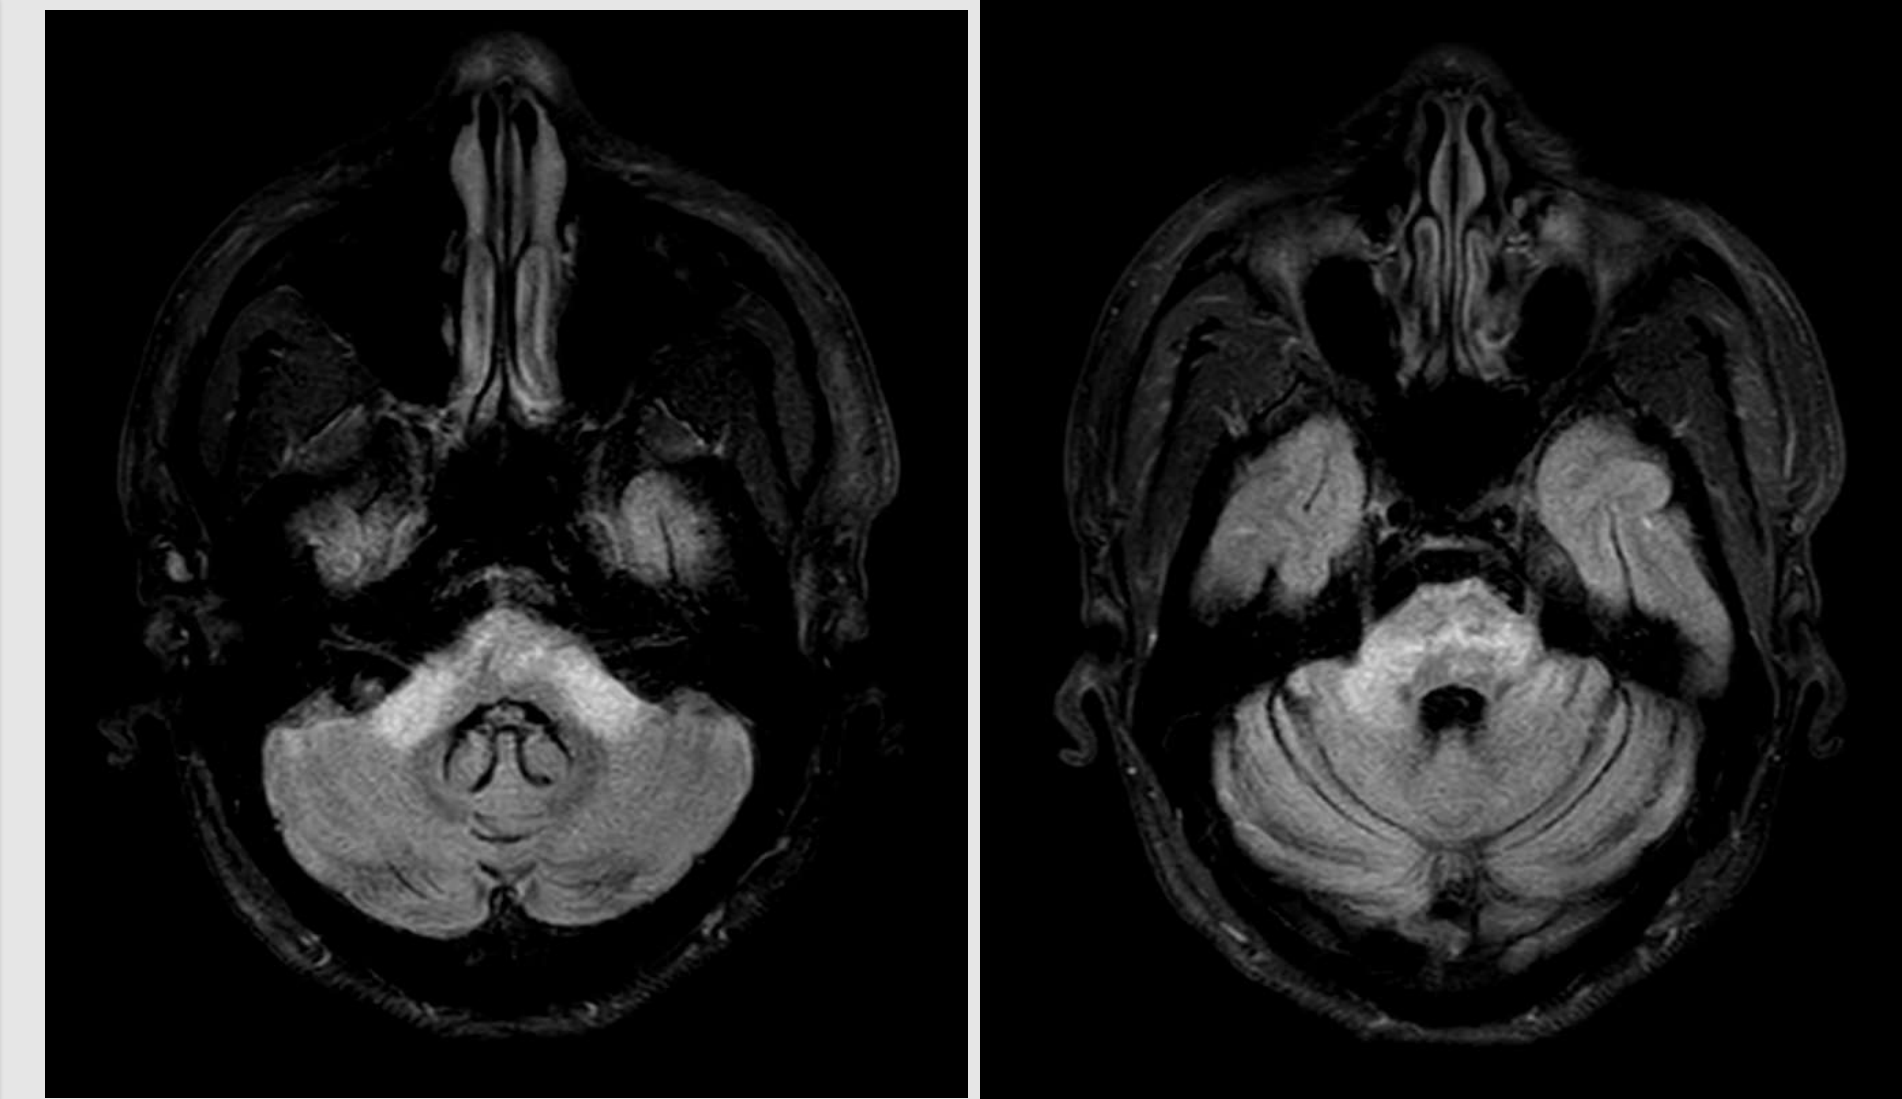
Axial FLAIR sequences of MRI brain showing hyperintensities in the cerebellar peduncles and brainstem
